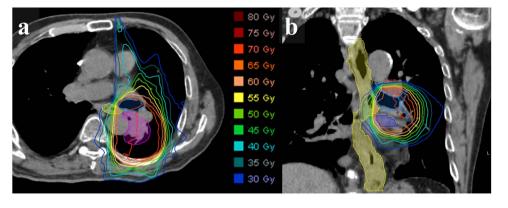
Imaging findings for an 88-year-old man with possible radiotherapy-related bloody sputum. (a) Axial and (b) coronal view of CT images with the dose distribution of accelerated hypofractionated radiotherapy.
